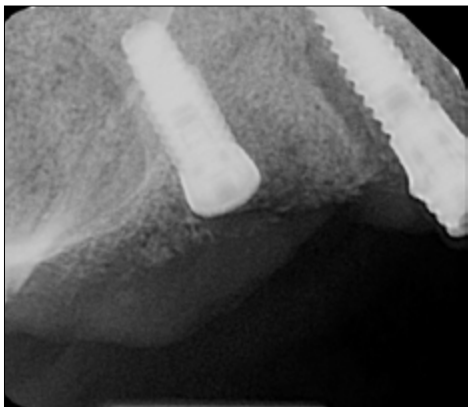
Periapical radiograph #3 area showing sinus graft.
